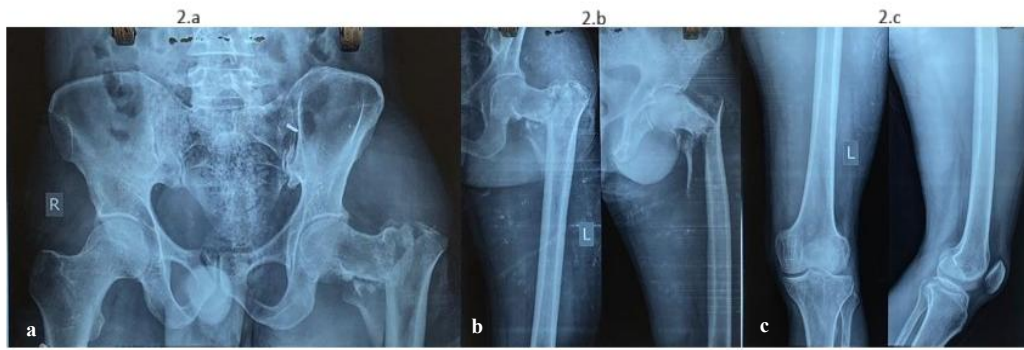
(a-n): Case 1, (a-c): Pre-operative X-ray, (d and e): immediate post-operative X-ray, (f-k): follow-up X-ray showing union and (l-n): clinical images at 1 year.
